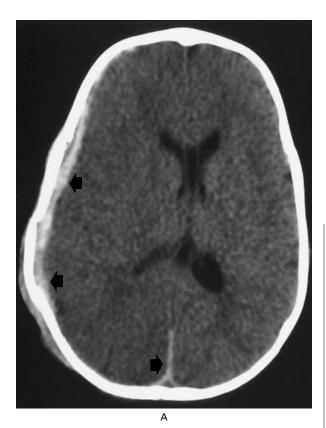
Axial Cranial CT Scans in an Eight-Month-Old Unresponsive Boy Found at Home.
